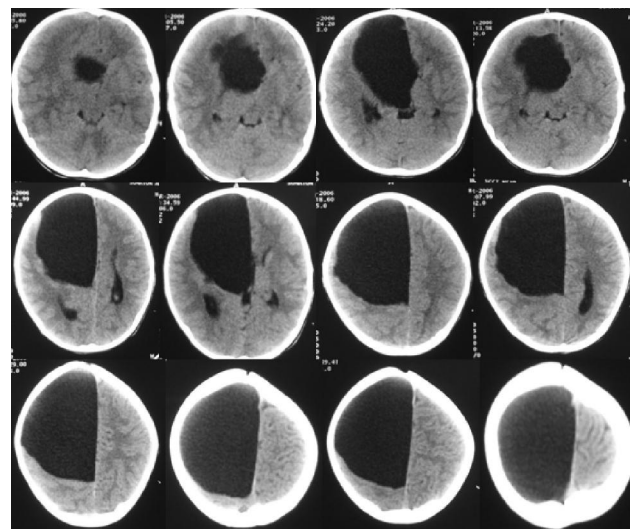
CT scan shows a large arachnoid cyst extending from suprasellar region, extending into the interpeduncular cistern and displacing whole of the right frontal lobe, lateral ventricle on right side pushed posteriorly. There is no evidence of hydrocephalus.
